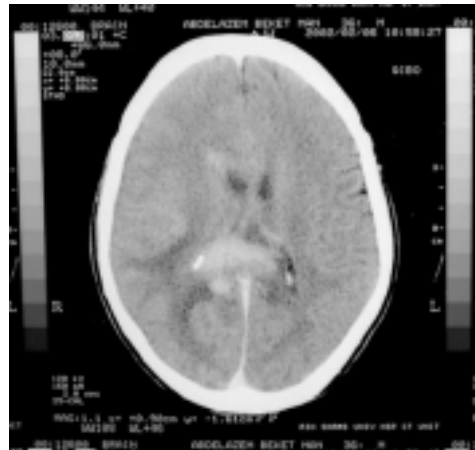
Patient 3, CT scan prior to treatment.
